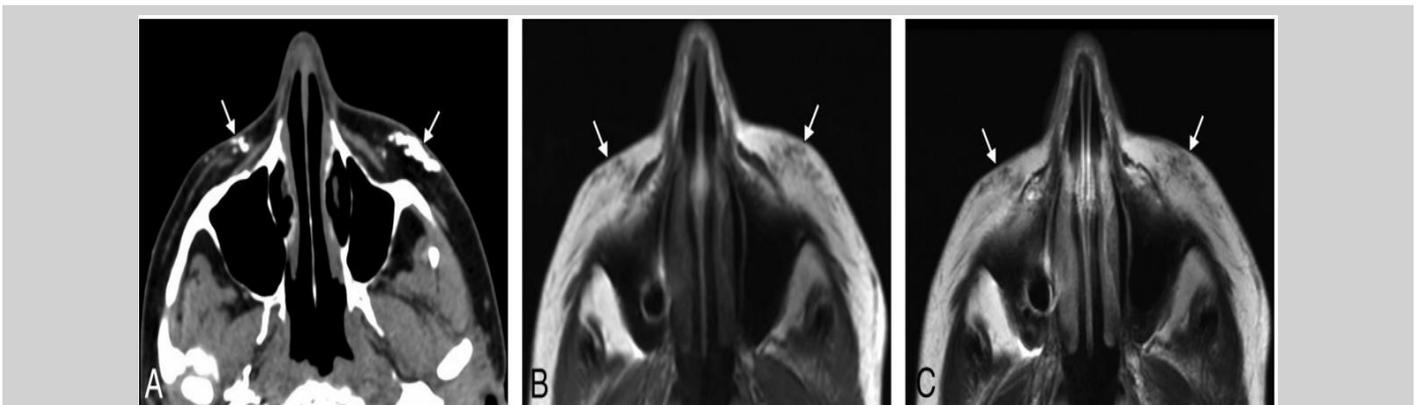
Axial non-contrast CT scan (A) shows hyperdense material within the bilateral subcutaneous tissues of the cheeks (arrows). Axial T1- (B) and T2-weighted (C) MR images demonstrate that the fillers exhibit low-to-intermediate signal intensity on both sequences (arrows).
